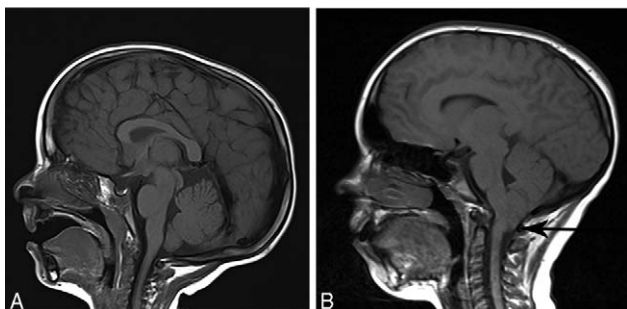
(A) MRI scan from patient 5 demonstrating a normal posterior fossa. (B) MRI scan from patient 7 revealing a Chiari malformation (black arrow points to area of tonsillar herniation). MRI, magnetic resonance imaging.
